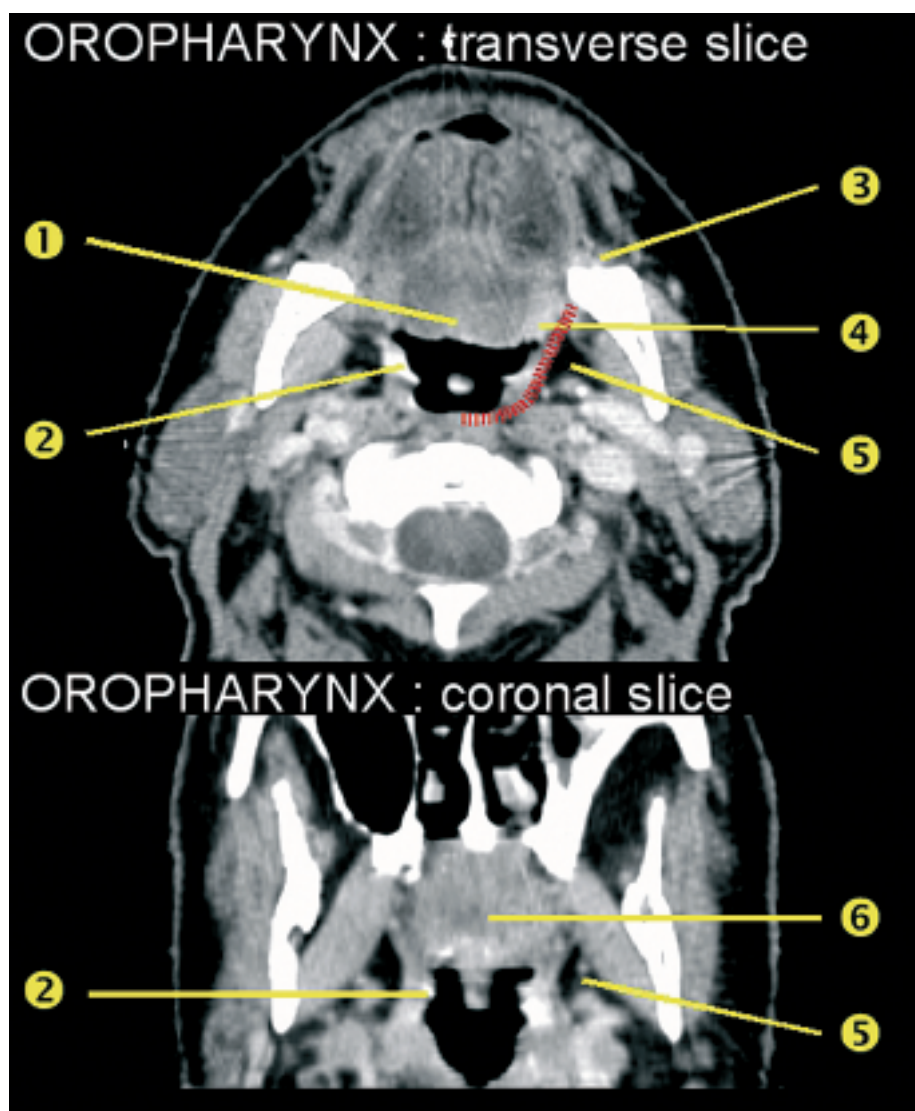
Normal anatomy of the oropharynx on CT slices. (1) Base of tongue. (2) Tonsilla. The constrictor muscles located just behind tonsilla are represented by the dashed red line on the contralateral part of the slice. (3) Retromolar trigone. (4) Glossotonsillar sulcus. (5) Parapharyngeal space. (6) Soft palate.
